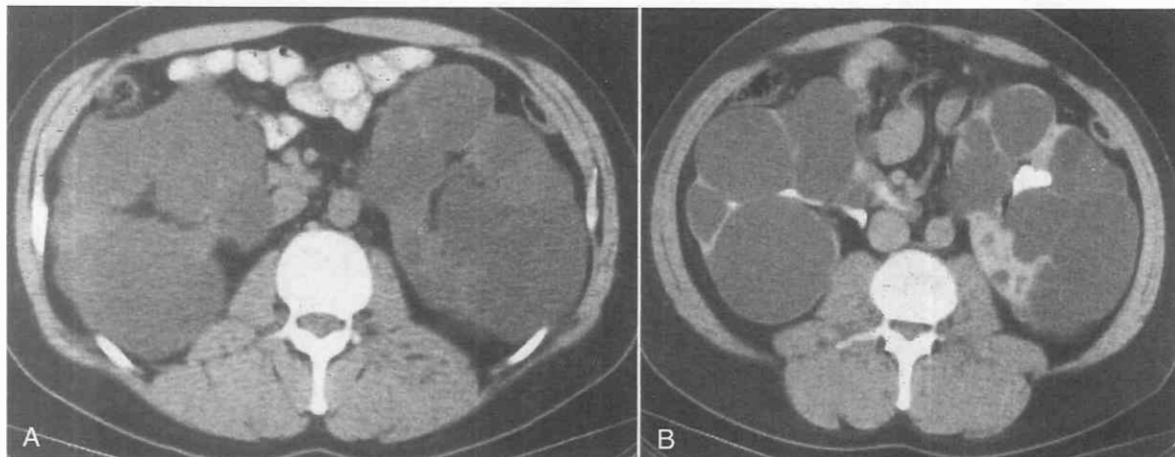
Autosomal dominant polycystic kidney disease in a 39-year-old man with hypertension and mildly impaired renal function. Unenhanced CT scan (A) shows bilateral nephromegaly. Contrast-enhanced CT scan (B) reveals large renal cysts with enhancing residual parenchyma between the cysts.
